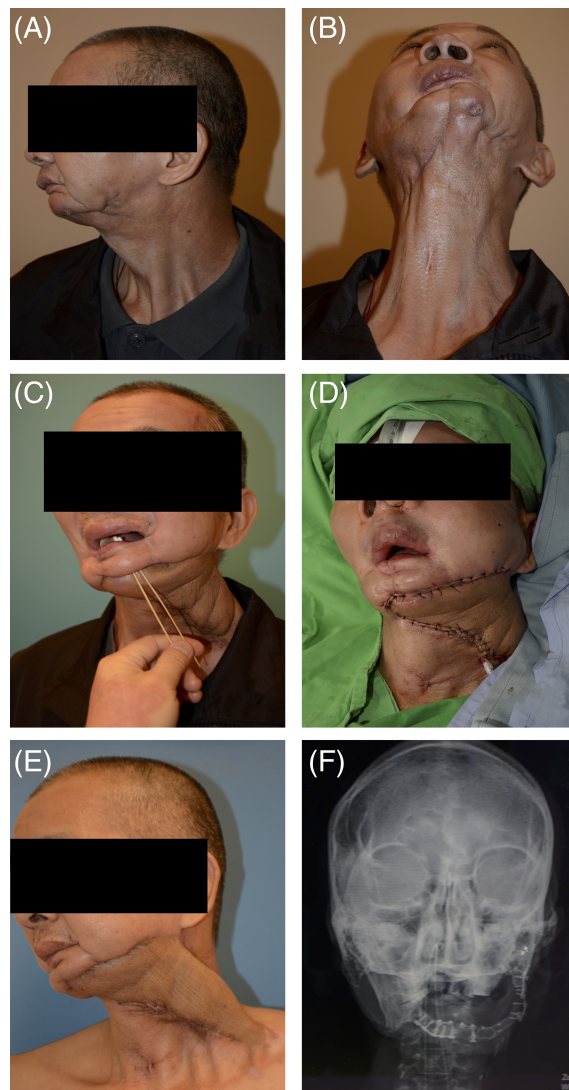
The patient presented with osteoradionecrosis of the left mandible. A and B, Preoperative pictures show severe contracture and skin fibrosis. C, Orocutaneous fistula on postoperative day 14 after the first stage procedure. D, Immediately post-operative picture after de-epithelialization of the skin paddle and repair of the orocutaneous fistula at the second stage. E, At 3-month follow-up, there was complete healing with no complications. F, A skull X-ray showing the reconstructed mandible with fixed plates
